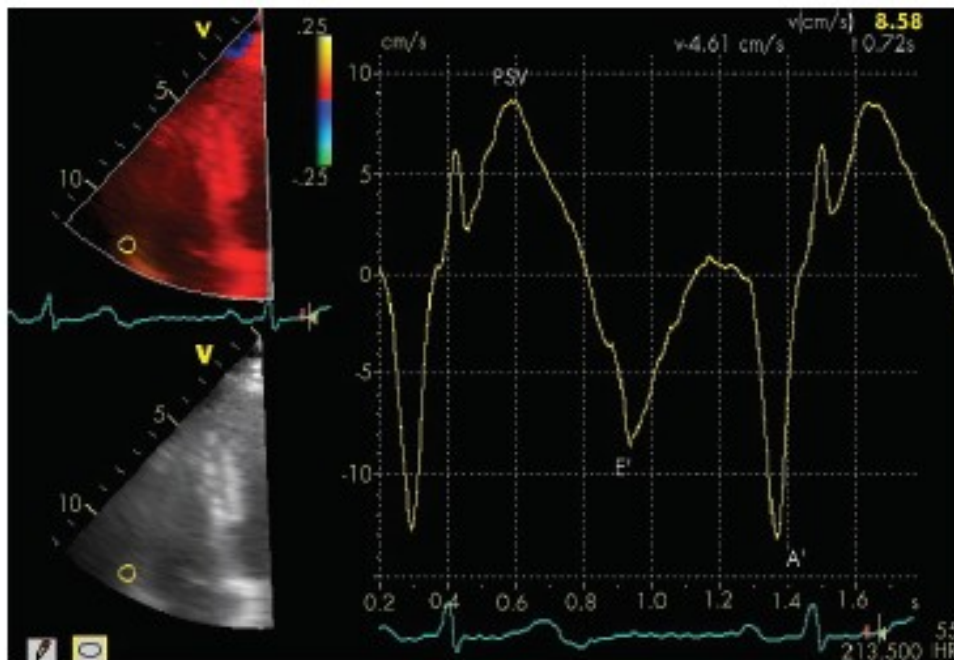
Tracing derived from colour coded tissue Doppler imaging with the sample placed at the level of the tricuspid annulus of the RV free wall, demonstrating peak systolic velocity (PSV), and diastolic velocities (E' and A').
